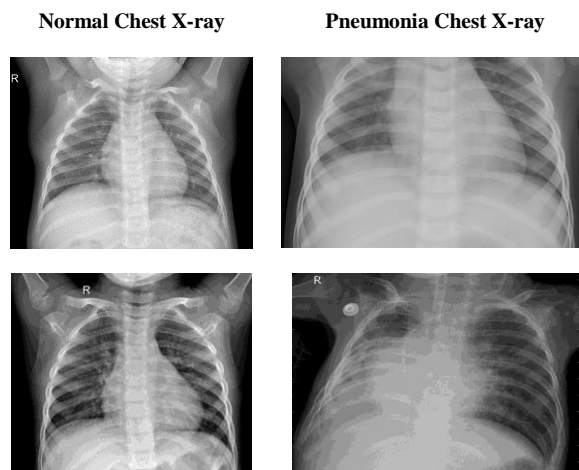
Representative Normal vs. Pneumonia chest X-ray samples
